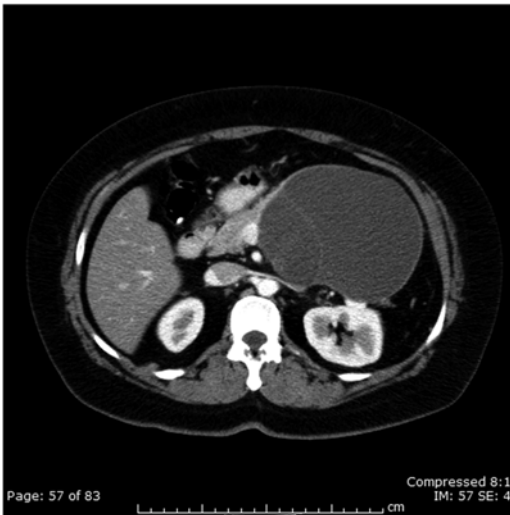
Radiological characteristics of MCNs. CT demonstrated a large 11-cm septated cystic lesion in the pancreatic tail in a middle-aged female patient presenting with left upper quadrant discomfort
